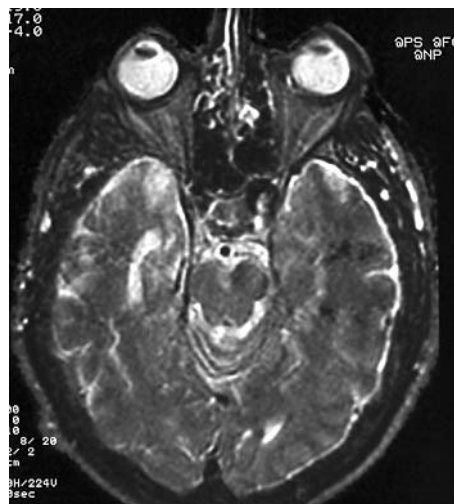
MRI shows a small area of high signal in temporal lobe with atrophic dilatation of temporal horn.
